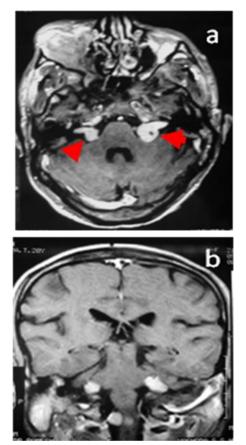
Fig 17ab: MRI - Bilateral acoustic schwannomas with bright signals (Same patient as in fig.16)
